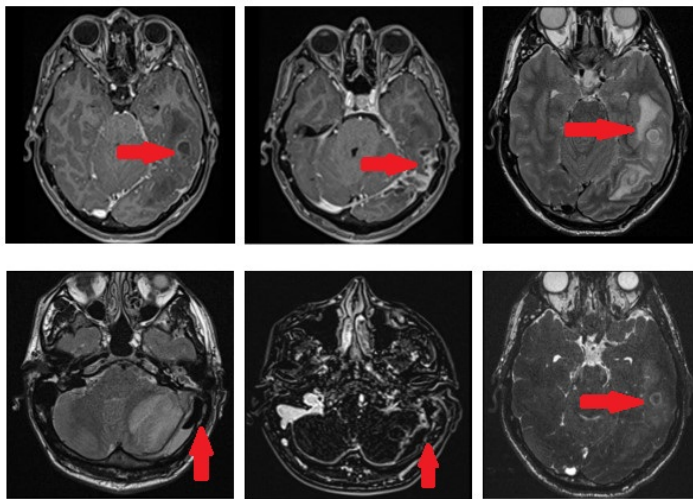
Brain MRI image performed with pre-diagnosis of brain abscess
